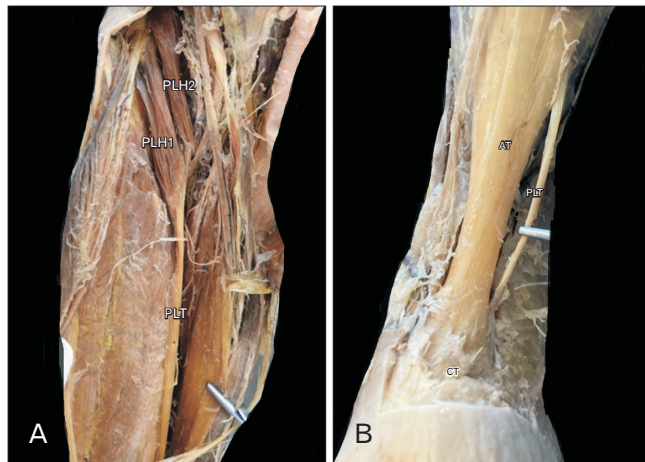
(A) The plantaris muscle variant. On the left lower limb, the plantaris muscular part consisted of two heads (PLH1, PLH2). (B) The plantaris muscle variant. On the left lower limb, the tendinous insertion of the muscle (PLT), at the calcaneal tuberosity (CT) medially to the Achilles tendon (AT).
